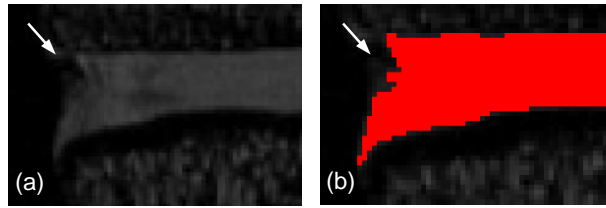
Unclear outer edge of annulus from MRI data for S3. The annulus boundary is unclear in the MR image (a). Mid segmentation (b). The mask shown was applied using a greyscale threshold. The arrow indicates the area that was later completed manually.
